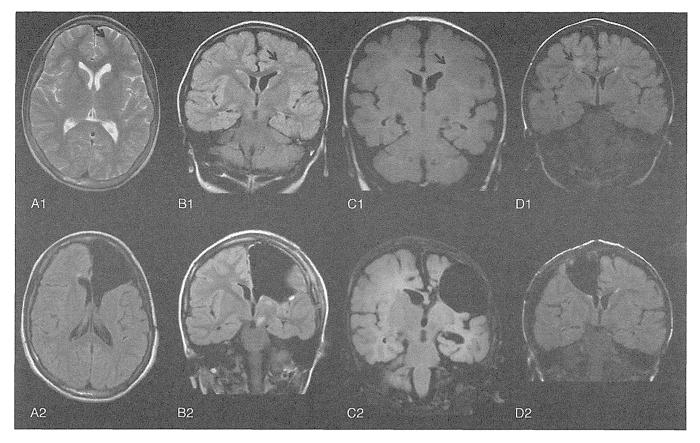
MRI of pre-operation and post-operation of subjects. A1 is pre-operation MRI, axial view/T2-weighted image, and A2 is post-operation, axial view/FLAIR image of case 1 in Table 1. B1 is pre-operation MRI, coronal view/FLAIR image, and B2 is post-operation, coronal view/FLAIR image of case 2 in Table 1. C1 is pre-operation MRI, coronal view/FLAIR image, and C2 is post-operation, coronal view/FLAIR image, and C2 is post-operation, coronal view/FLAIR image, and D2 is post-operation, coronal view/FLAIR image of case 3 in Table 1. D1 is pre-operation MRI, coronal view/FLAIR image, and D2 is post-operation, coronal view/FLAIR image of case 4 in Table 1. Arrows indicate abnormal signals in the white matter and/or neocortex. In B1, there is definitive laterality of the caudate nuclei.
